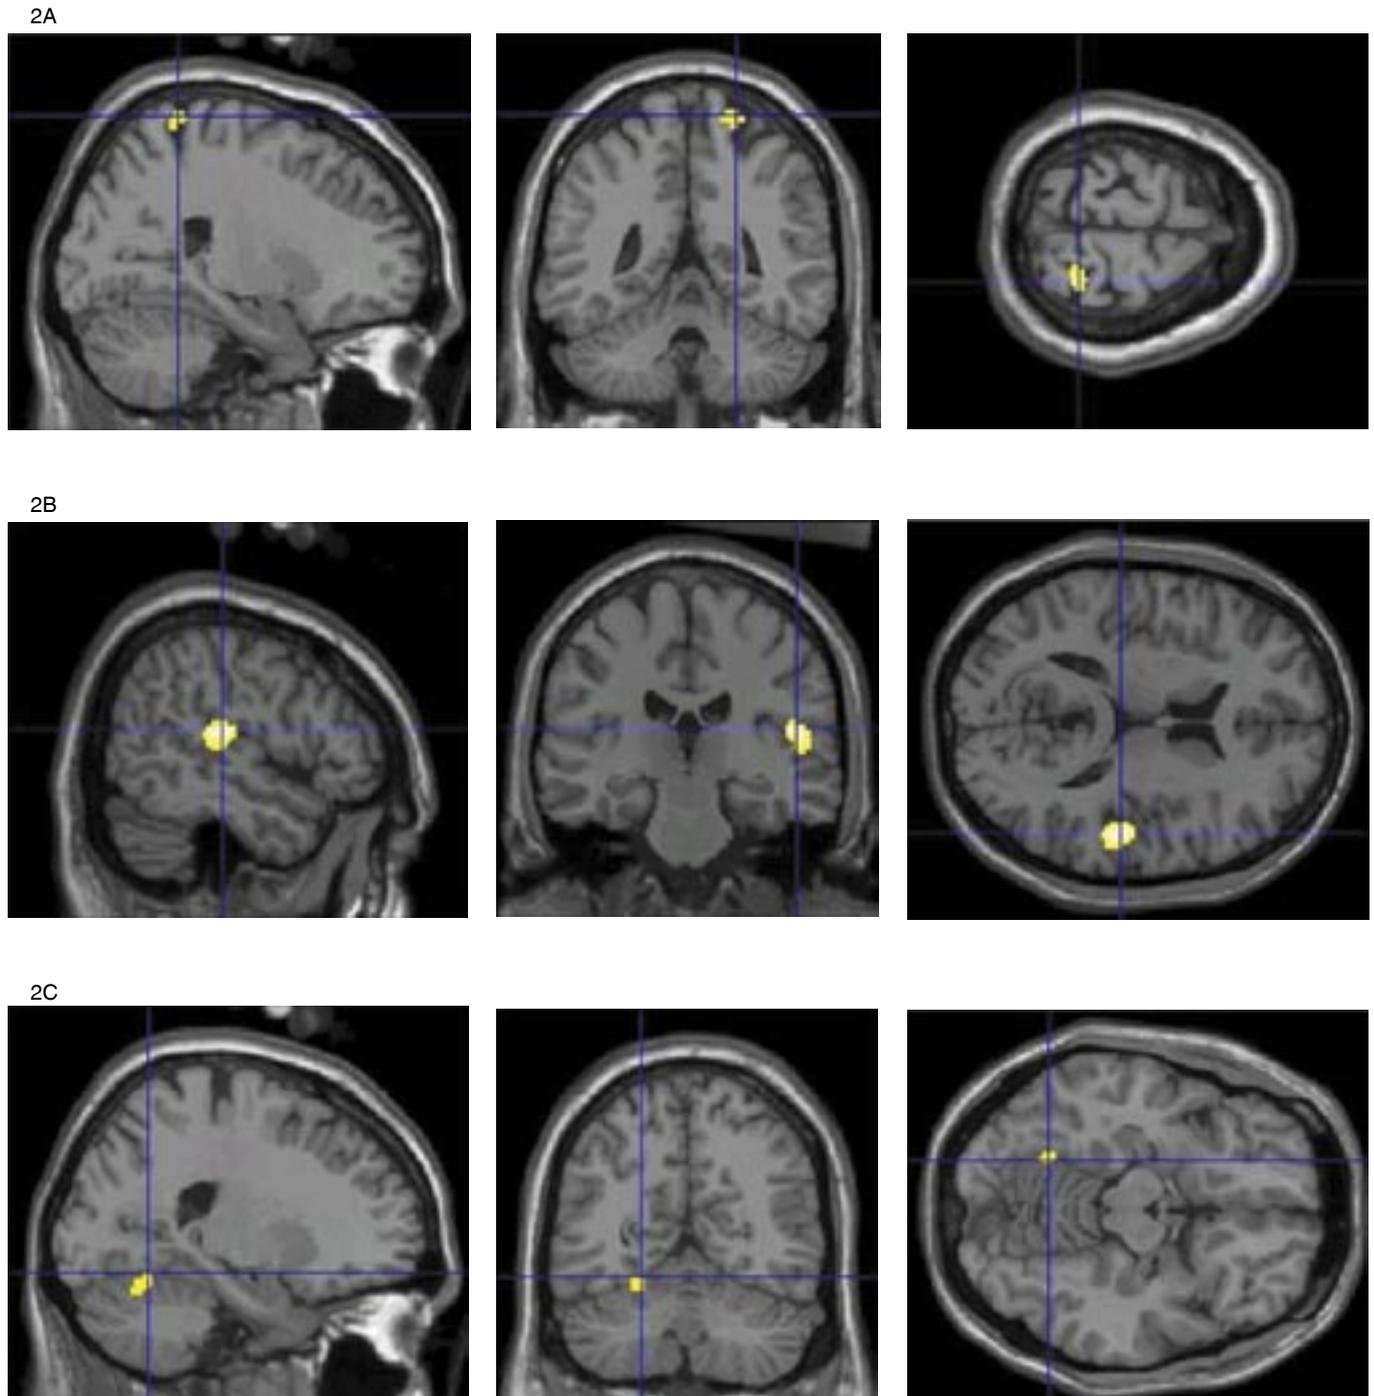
A, B, C: Regions with higher  $^{18}\text{F}$ FDG PET metabolism in patient with DP/DR syndrome compared to controls. 2A right superior parietal gyrus, 2B right superior temporal gyrus/ inferior parietal gyrus, 2C left fusiform gyrus in the occipital lobe. Regions are superimposed to the SPM MR template. Detailed characteristic of detected area are in the Table 1.
